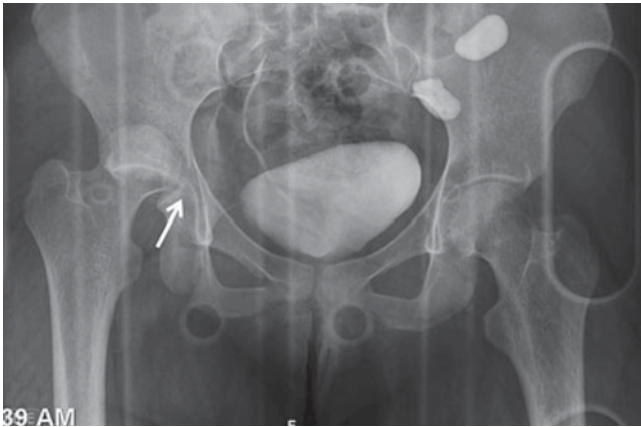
A 16 year-old girl was a passenger in motor vehicle collision. Patient presented to the emergency room with right hip pain. Radiograph of the pelvis shows right hip dislocation (notice the empty right acetabulum (arrows) compared to left hip). (Courtesy of Dr Pirela-Cruz)
